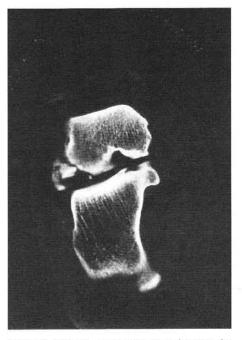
Coronal section CT scan showing the degree of comminution, and intra-articular nature of the fracture.
